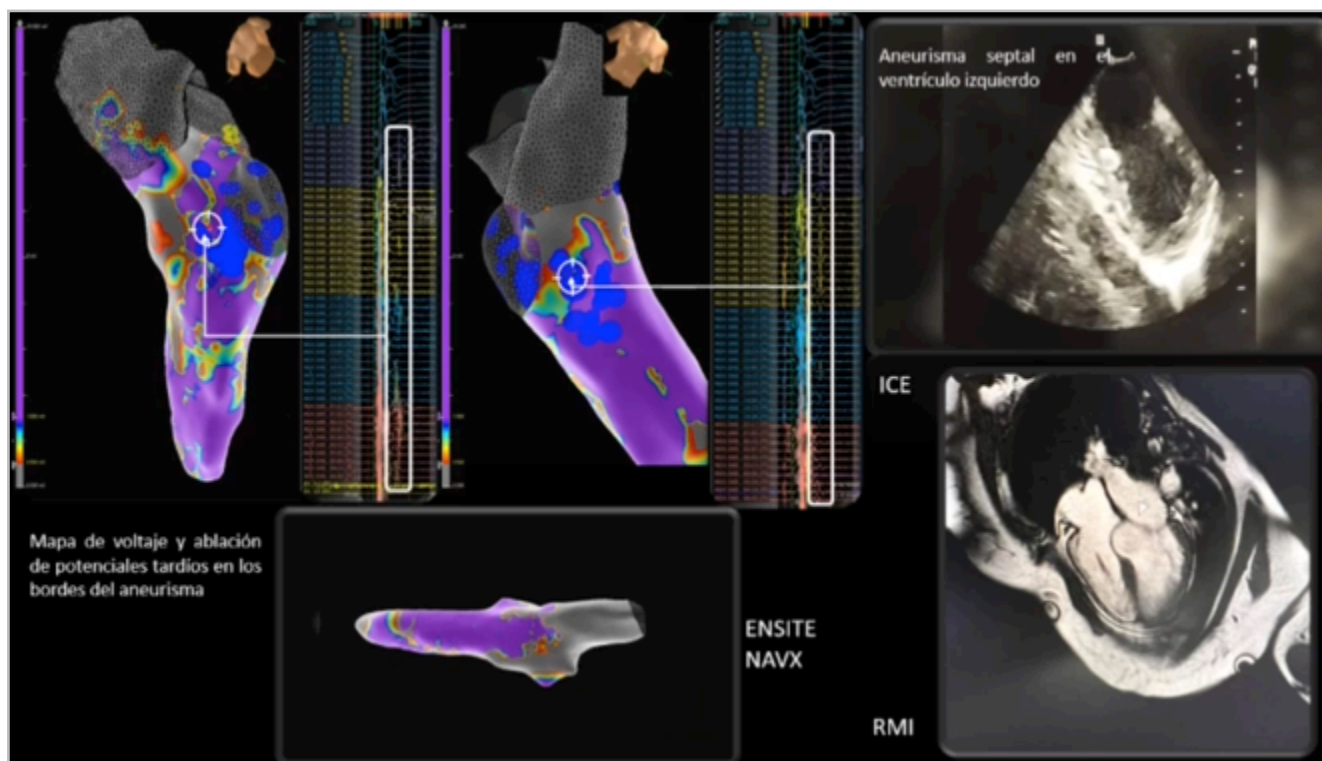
Basal septal aneurysm seen on EnSite. A septal aneurysm is shown on the right, using echocardiographic and magnetic resonance imaging.
